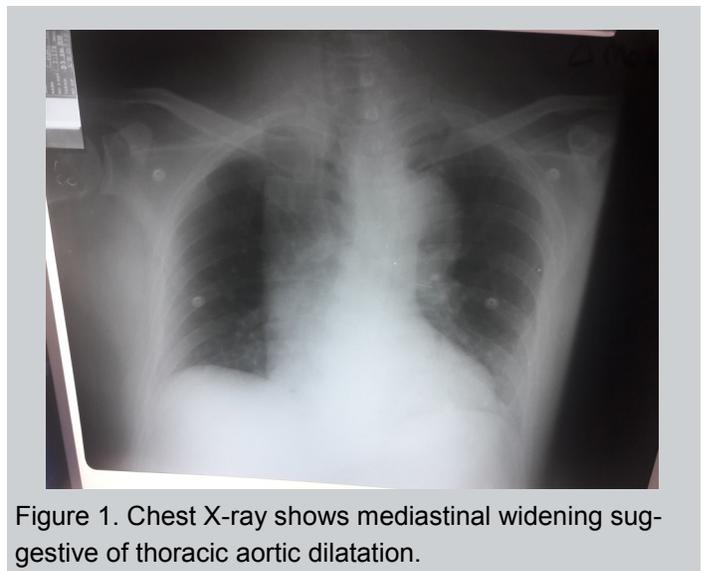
Chest X-ray shows mediastinal widening suggestive of thoracic aortic dilatation.
